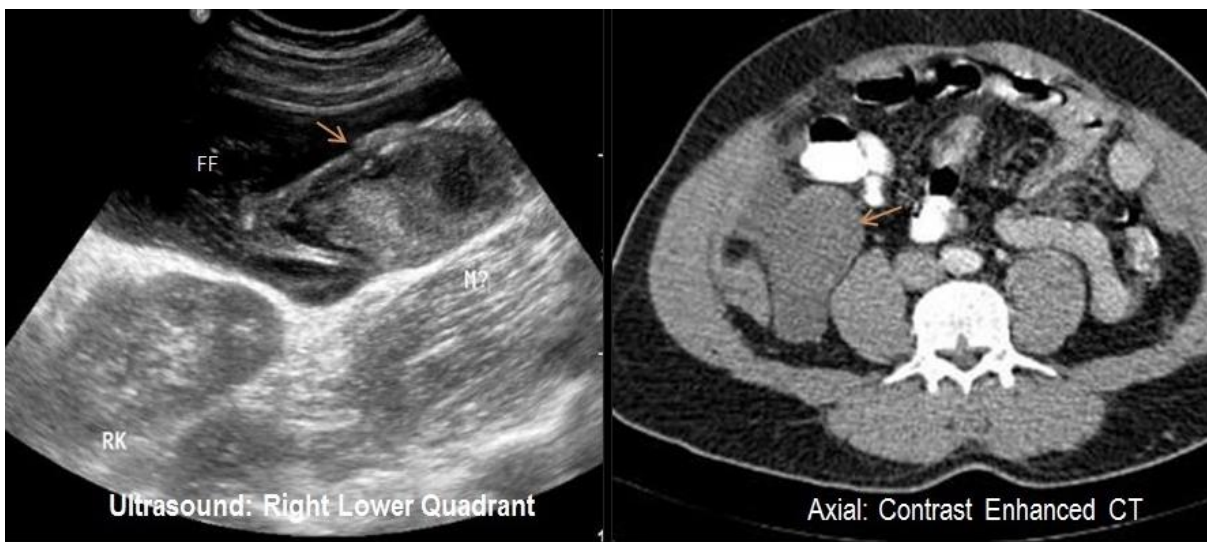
Ultrasound and Axial Contrast Enhanced CT. Dilated appendix with luminal diameter of 3.6cm with high density fluid endoluminal contents, thin rim of peripheral calcification with a focal defect s/o perforation and regional collection with fat stranding.
